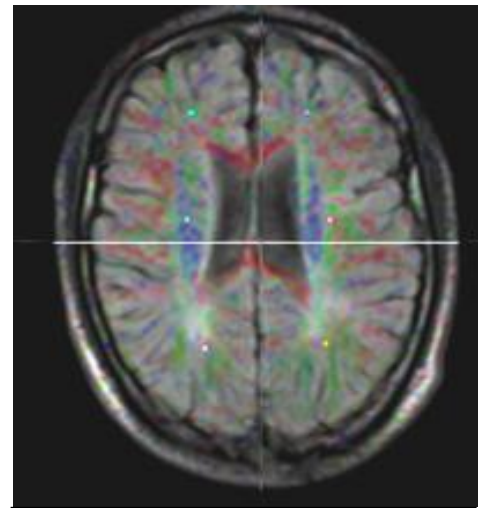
Case (4) fused FLAIR/DTI Axial image
